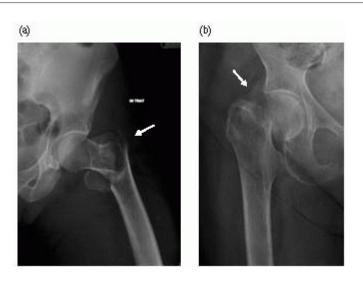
Close-up of radiographs showing (a) an intertrochanteric fracture on the left; (b) fractured neck of femur.
